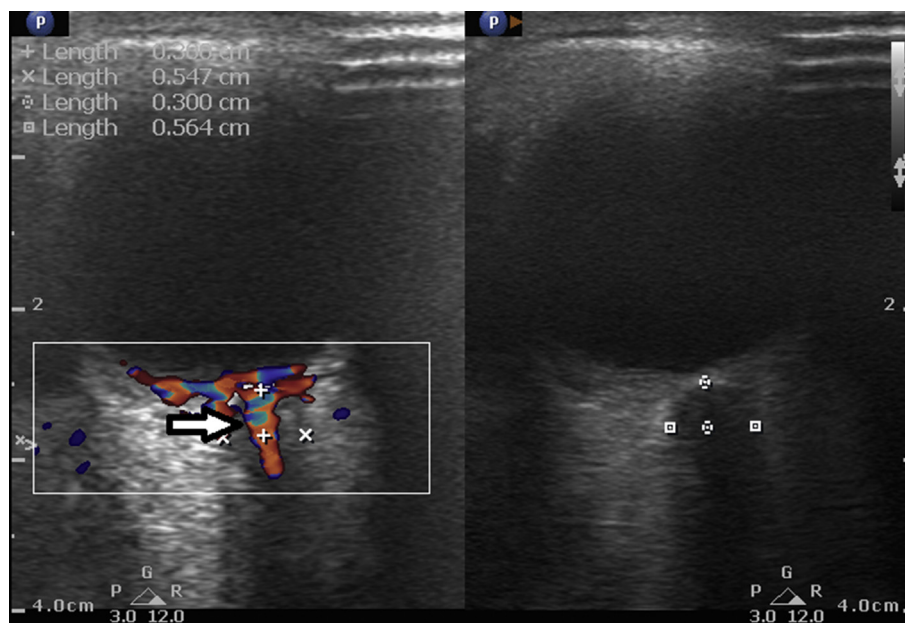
Optic nerve in children can be tortuous. Since the central retinal artery (white arrow) passes centrally through the optic nerve, color Doppler will help the examiner to correctly identify the optic nerve and avoid errors in interpreting the ONSD.
